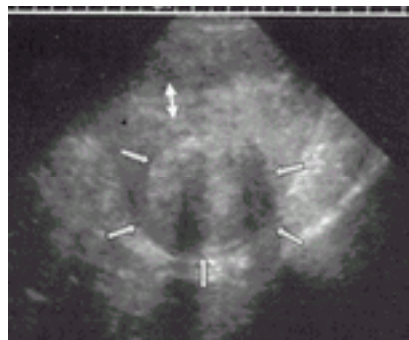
Ultrasound of uterine leiomyoma. This is a transvaginal ultrasound in a woman who has an intramural myoma (*arrows*). The myoma clearly does not impinge on the endometrial cavity with intervening myometrium. The endometrial stripe is defined by a *double arrow*.
